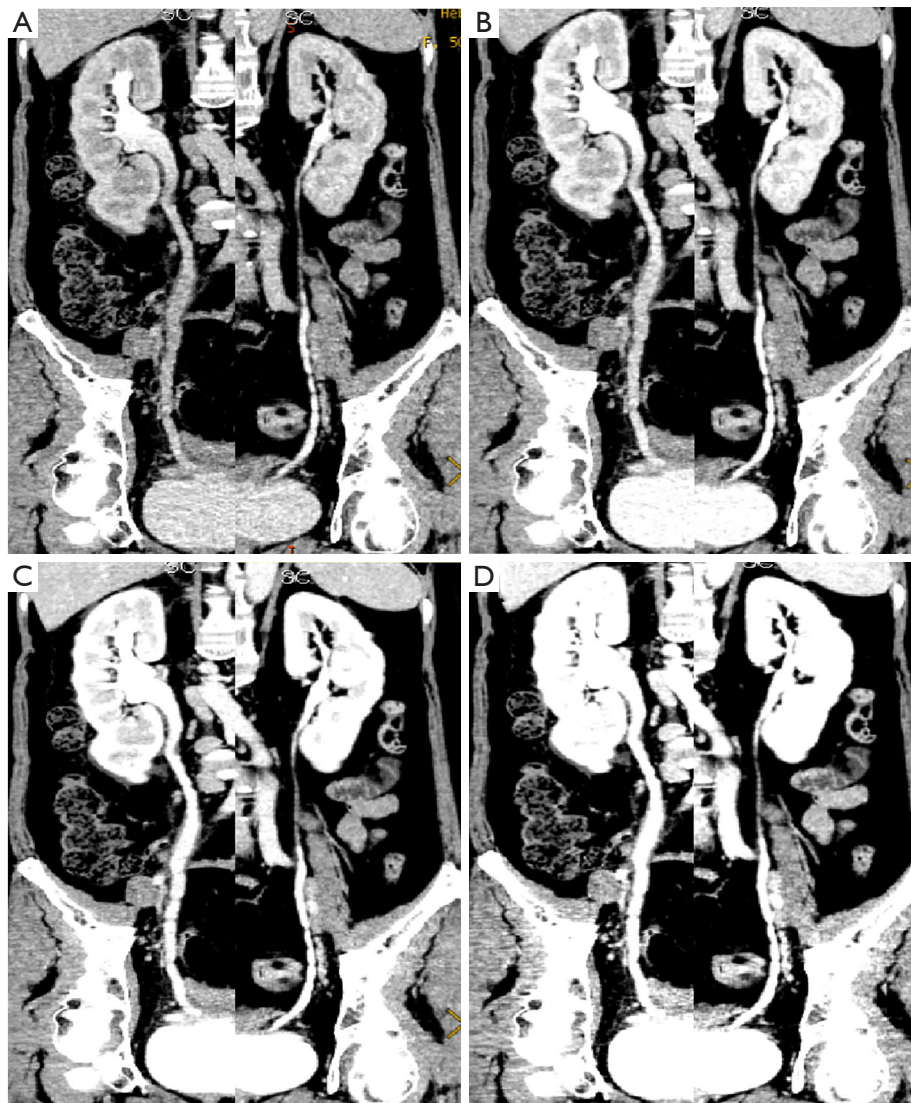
Monochromatic images. The coronal monochromatic images reconstructed at the single energy of 90 keV (A), 80 keV (B), 70 keV (C), and 60 keV (D), respectively, showing that the CT values of the urinary tract increased significantly with the decrease of the single energy. CT, computed tomography.
